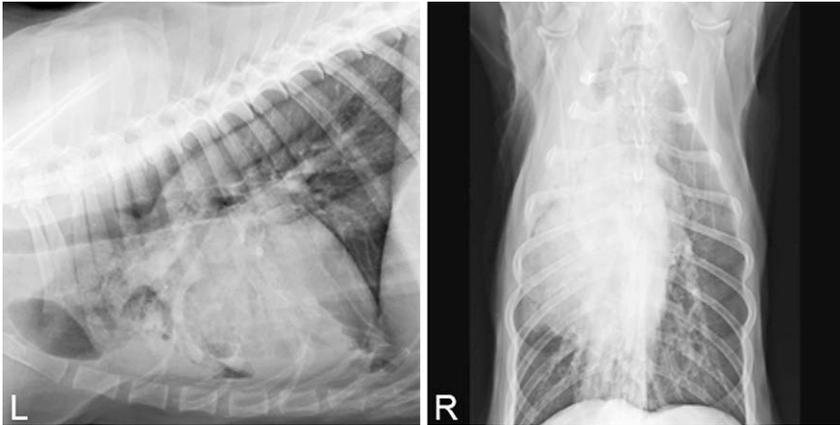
Orthogonal thoracic radiographs of an 11-year-old, FS, Akita with vomiting, fever, and difficulty breathing attributed to pneumonia. Note that the right-cranial and right-middle lung lobes have an increased opacity that completely obscures pulmonary blood vessels and creates air bronchograms. Additionally, these lung lobes are not fully inflated, as the heart is shifted to the right, and the left-cranial lung lobe is hyperinflated, crossing midline more than normal. In this case, the atelectasis is attributed to aspiration pneumonia.
